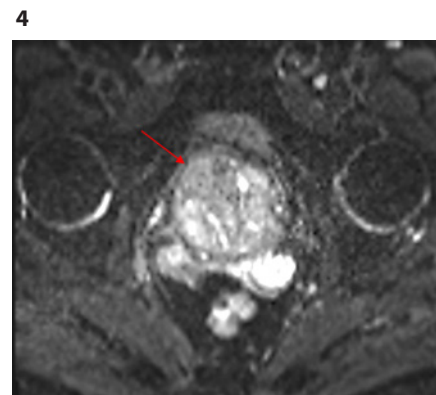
Lesion in the mpMRI (T2-weighted sequence) described as a BPH nodule classified as PI-RADS 2 located in the anterior part of the prostate on the right side marked with a red arrow.
